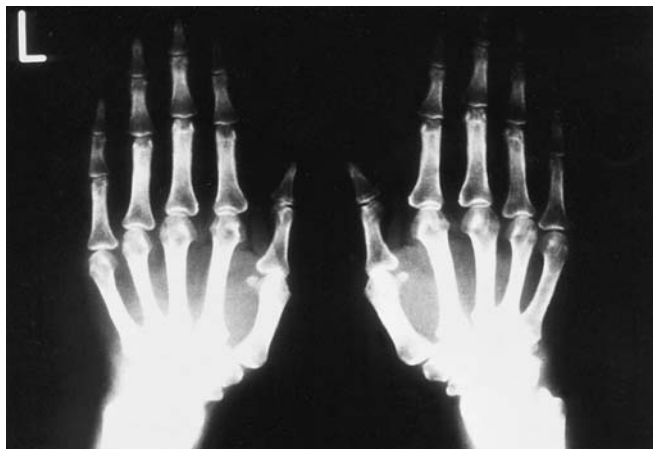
Case 1. Radiograph of the patient's hands in 1993
